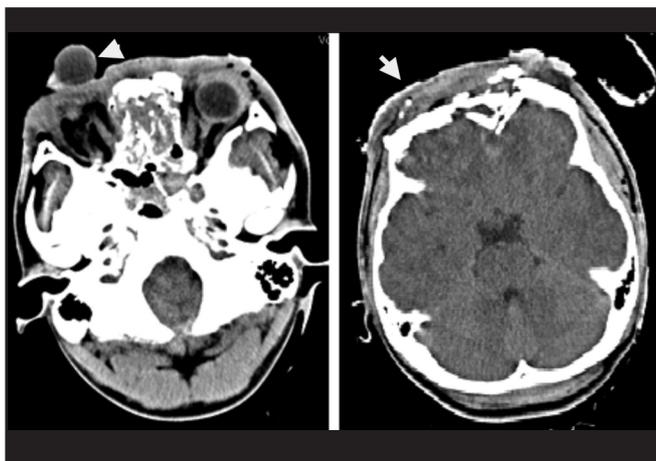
(a) axial CT scan at mid-orbit level depicting the avulsed right globe (white arrow). (b) axial CT scan at higher level showing extensive frontal bone comminuted fracture (white arrow) and generalised cerebral oedema.
